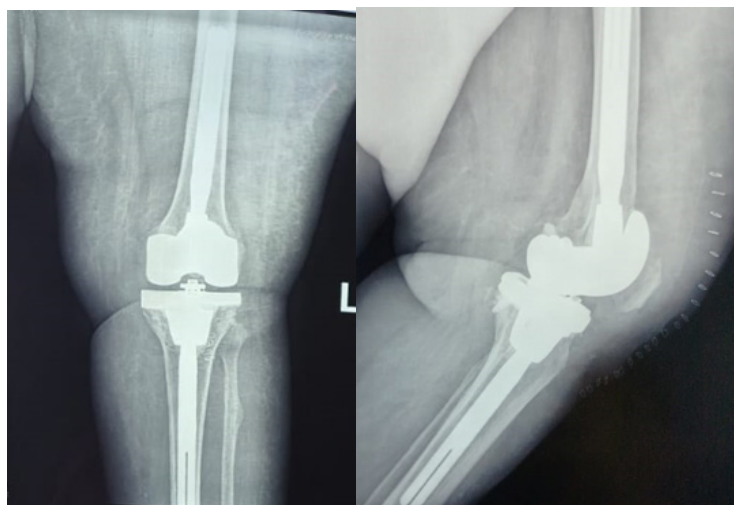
Post Operative Left Knee Anteroposterior and Lateral Radiographs
